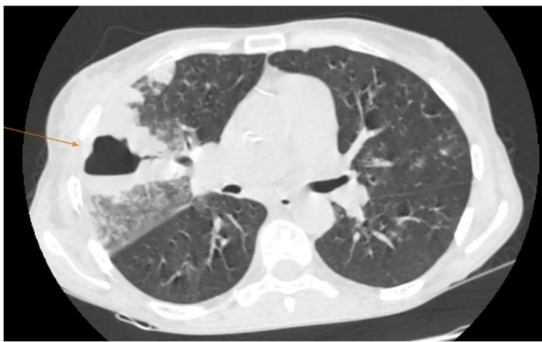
Contrast-enhanced chest CT: diffuse areas of reduced transparency in the right upper lobe anterior and posterior segments with a "ground glass" appearance, with a confluent character and organization in condensation areas, with an air bronchogram, tangential to the parietal pleura and to the fissures, and two hydroaeric images with dimensions of approximately 46/33 mm and 22/17 mm (arrows).
